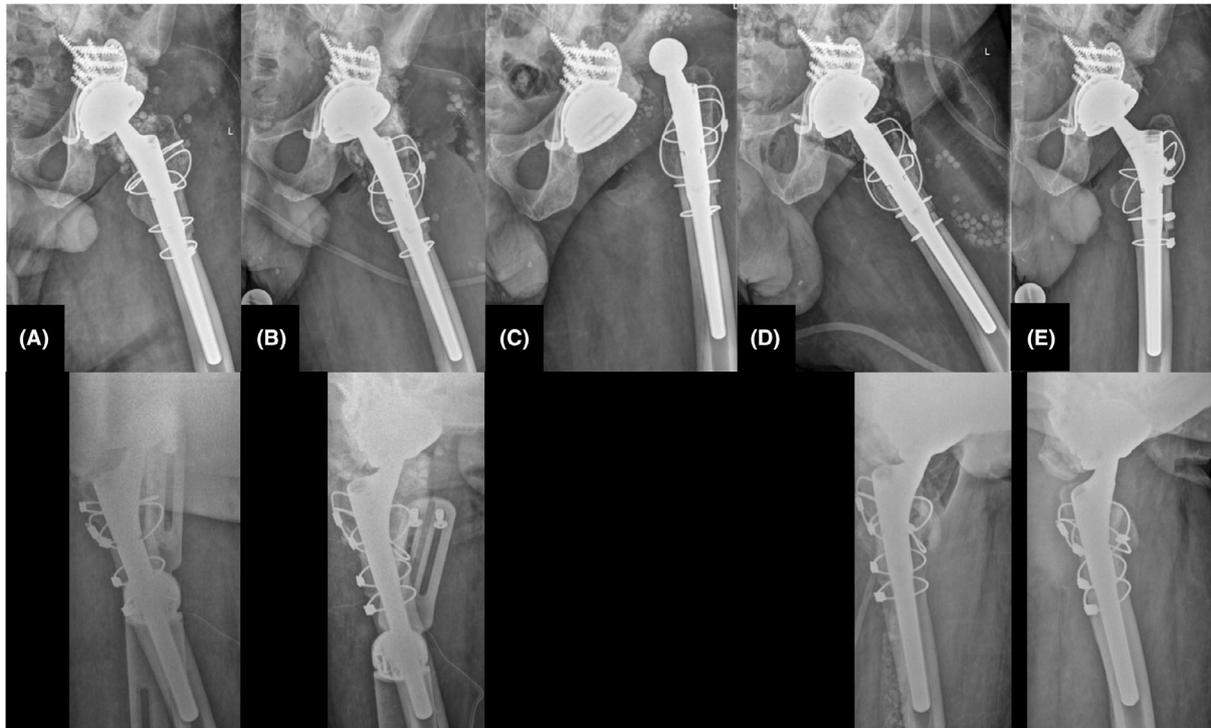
Anteroposterior (upper row) and axial (lower row) radiographs of the left hip of Case two. (A) Situation before and (B) Situation right after revision with replacement of the modular components and application of CaSO₄ loaded with amphotericin B, vancomycin and ceftriaxone due to *Candida tropicalis* PJI developed within 4 weeks after treatment of *Escherichia coli* PJI. Note the periarticular, radio dense CaSO₄ pellets as well as on the axia views the metal strut that are part of the patient's abduction orthosis. (C) Anteroposterior radiograph of the dislocated THA 17 days after revision. No closed reduction of the dual mobility cup/head was possible, requiring open reduction. (D) Situation after open reduction and mesh tube (LARS; Corin, Buchs, Switzerland) reinforcement of the THA. After debridement, repeated application of CaSO₄ with amphotericin B was performed. (E) Follow-up 4 months after implantation of THA, 10 weeks after first revision and 8 weeks after the last implantation of CaSO₄ added with amphotericin B. not complete dissolution of the pellets.
